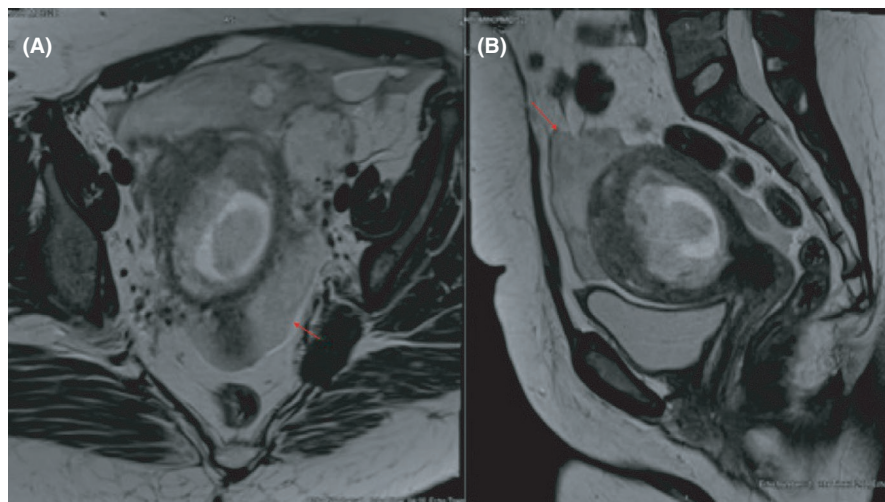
MRI T2 WI. Shows hemoperitoneum (clotted blood) as intermediate signals anterior and superior to the uterus.
